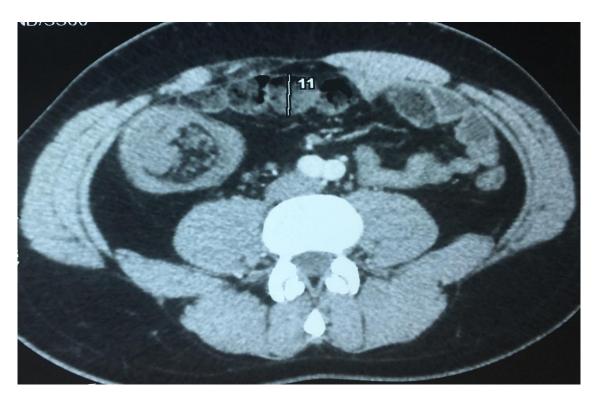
Ileocecal intussusception seen on transverse cut of abdominal CT scan with IV contrast (cockade aspect)
